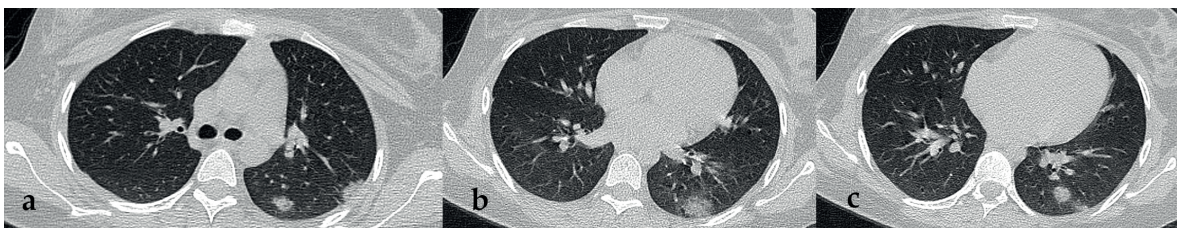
A-17-year-old girl with COVID-19 pneumonia. (a-c) Axial non-contrast enhanced chest CT images demonstrate subpleural ground-glass nodules in the left lower lobe.
